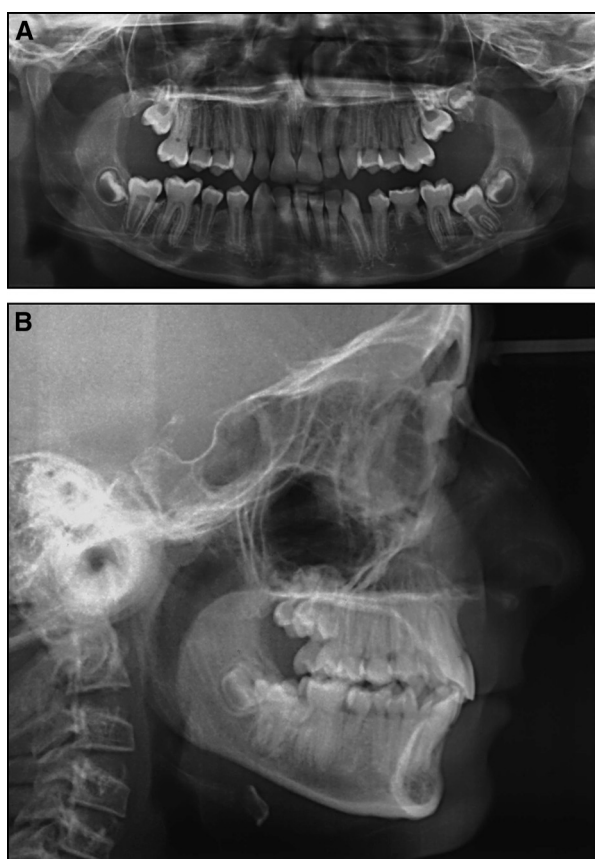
Pretreatment radiographic records in patient 3: A, panoramic radiograph; B, lateral cephalogram.
